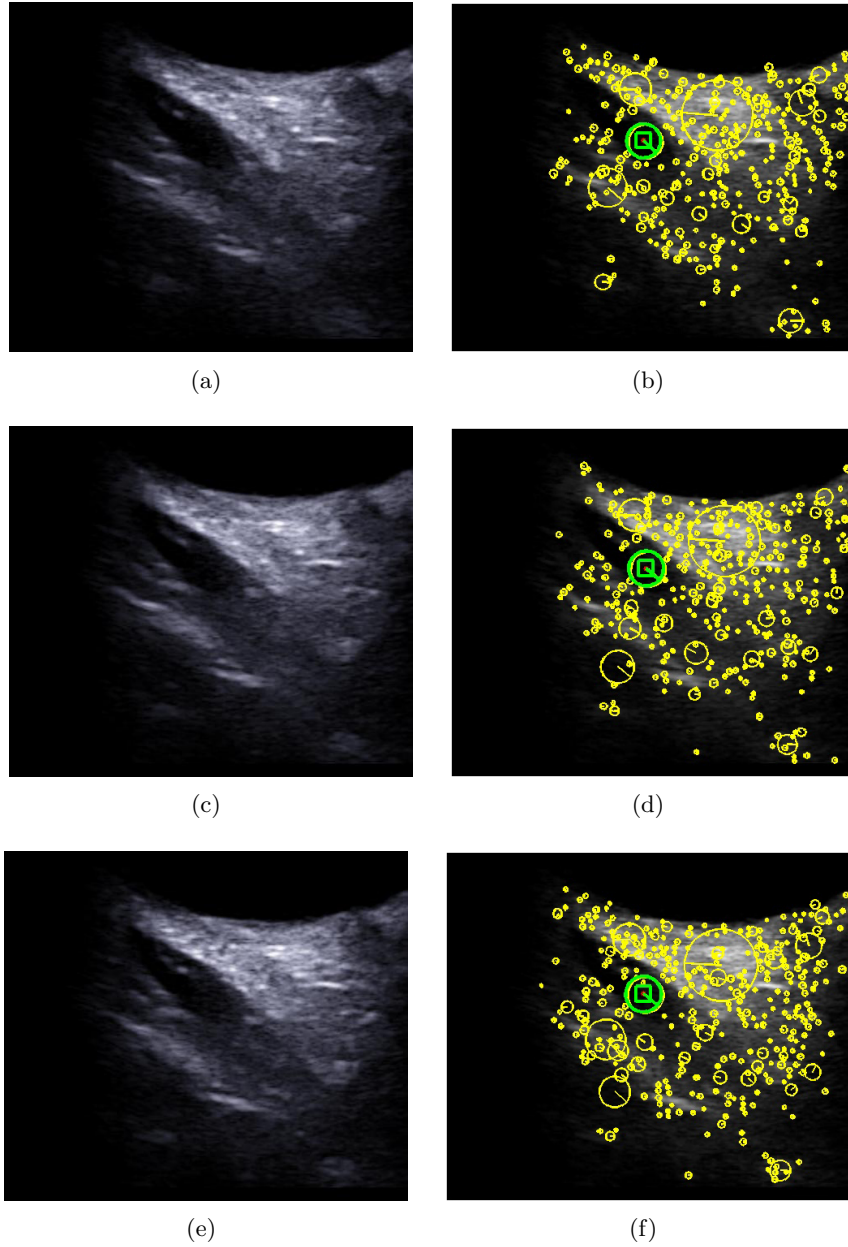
Ultrasound image of the lateral rectus muscle in multiple frames. Left - raw image; Right - motion tracking through SIFT feature, One of the corresponding features detected in the continuous time frame was overlaid in green which showed local muscle motion to the up right direction along the muscle long axis
